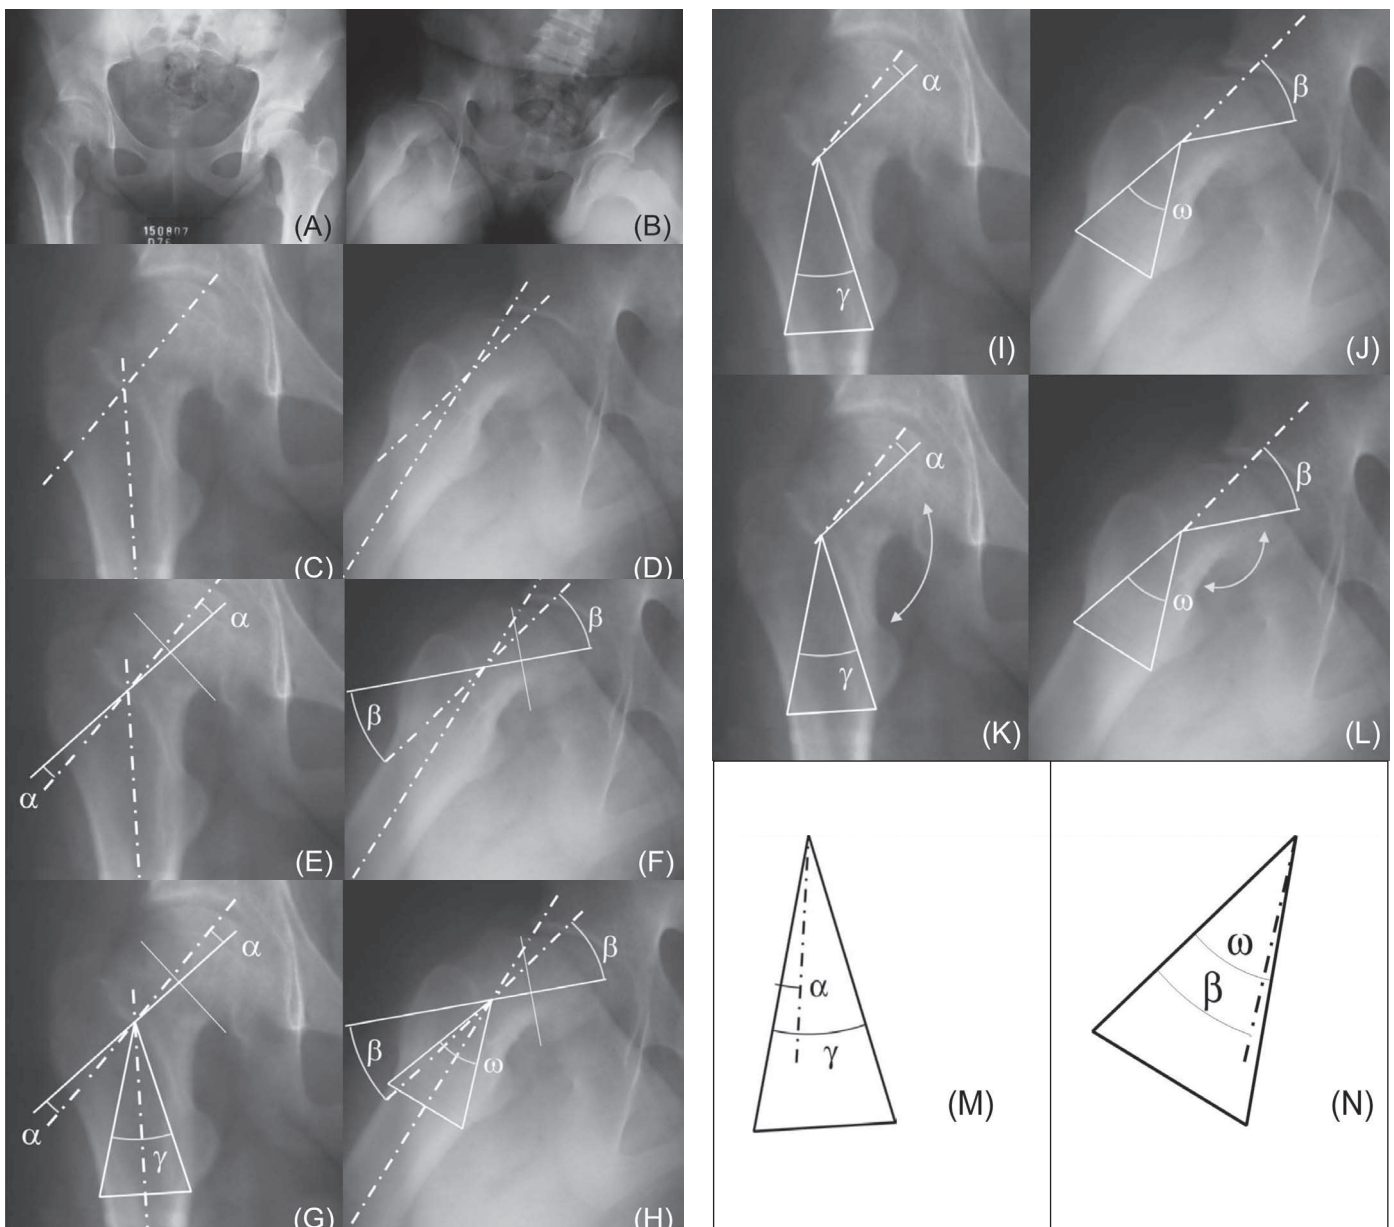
Method for calculating the estimate for the critical angle: radiographs in anteroposterior view (A) and lateral view (B), showing the proximal femoral epiphyseal slippage to the right; (C) and (D), the definition of the cervical-diaphyseal angles in the anteroposterior and Lauenstein views; (E) and (F), measurements of the correction angles α and β ; (G) and (H), determination of the critical angles γ and ω ; (I), (J), (K), (L), (M) and (N), isolation of the critical angles in the anteroposterior and Lauenstein views and comparison with the angles needed for correction
